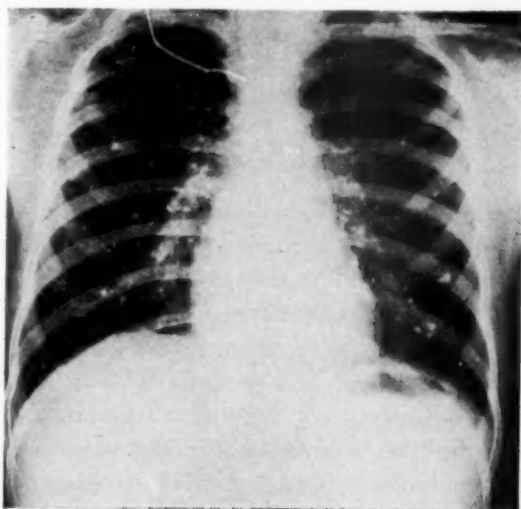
Chest x-ray of 12-year-old son of patient demonstrating wide-spread calcifications of histoplasmosis.
